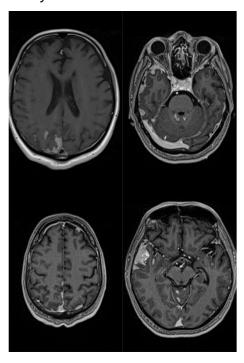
MRI at diagnosis showed multiple lesions structured nodular and in plaques with a tumor appearance, localized predom inantly leptomeningeal as well as capsulo-len ticular on the right side, and which associate mass effect on the right anterior temporal pole. The evaluation of the smear from the cerebrospinal fluid sediment revealed cellu larity consisting of frequent plasma cells. Im munofixation of the cerebrospinal fluid revealed the IgA lambda compact band.
